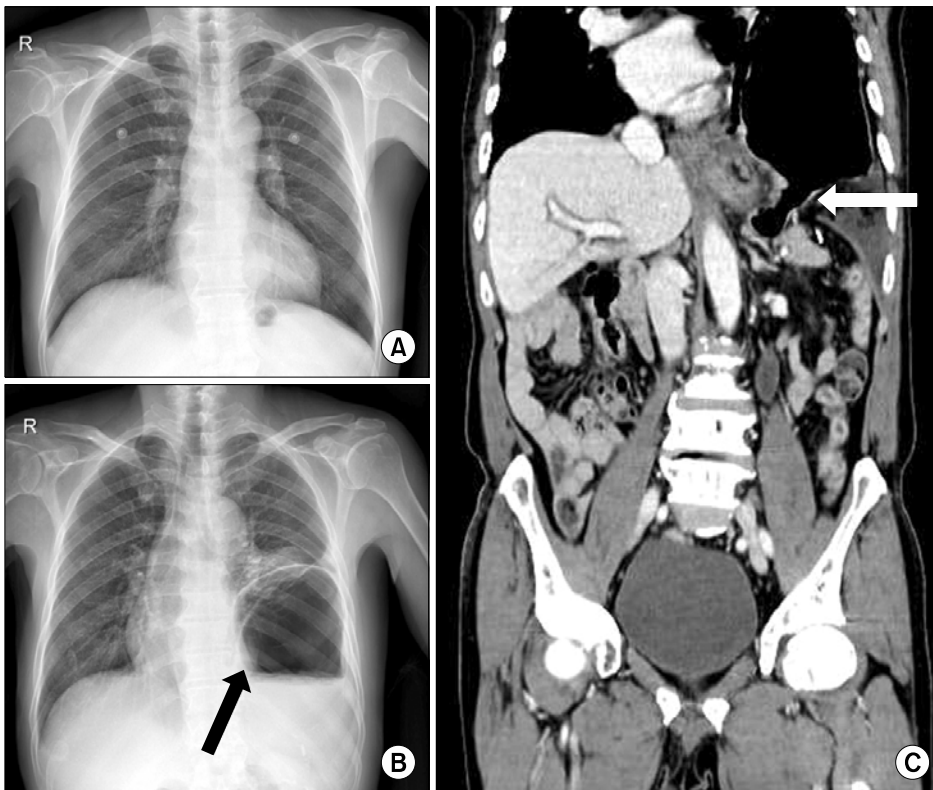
The patient had a normal chest X-ray four months earlier (A). A new chest X-ray (B) and computed tomography (C) revealed that the stomach had migrated into the thoracic cavity. A black arrow (B) points to the stomach, which is extremely inflated by ingested air. A white arrow (C) points to a 5 cm defect of the diaphragm. The diaphragmatic dome is suspected to be a perforated site.
